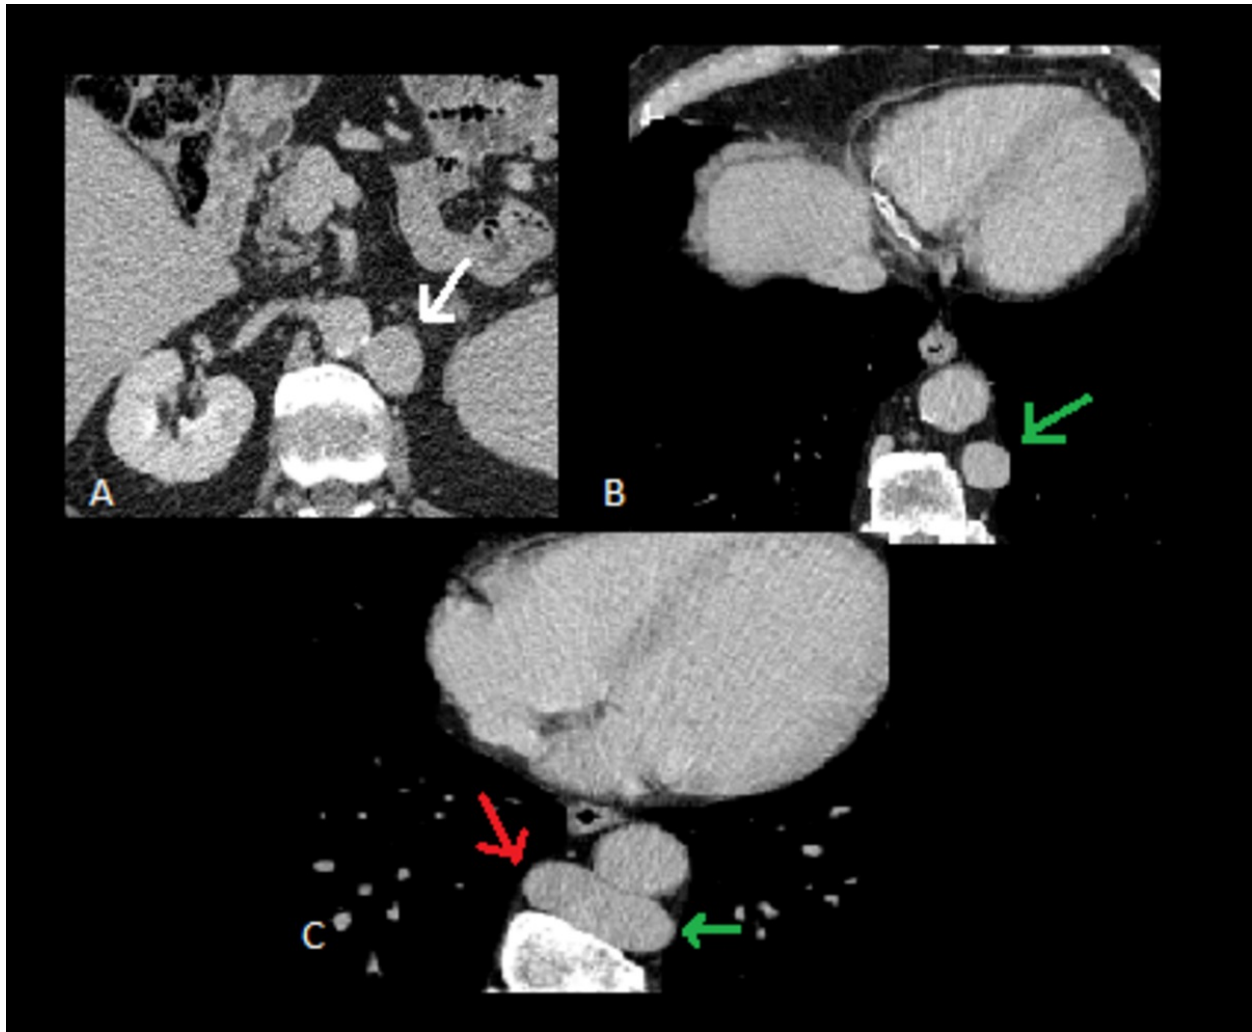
Left IVC interruption with hemiazygous continuation. Contrast-enhanced CT scans shows hemiazygous continuation (green arrow) of a left-sided IVC (white arrow). The hemiazygous vein joins the azygous vein (red arrow).
